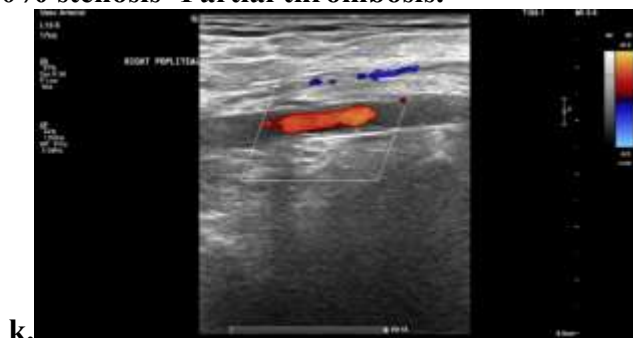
Image k. Color doppler image longitudinal section of right popliteal artery showing patchy color flow. Echogenic content noted causing 20-30% stenosis - Partial thrombosis.
